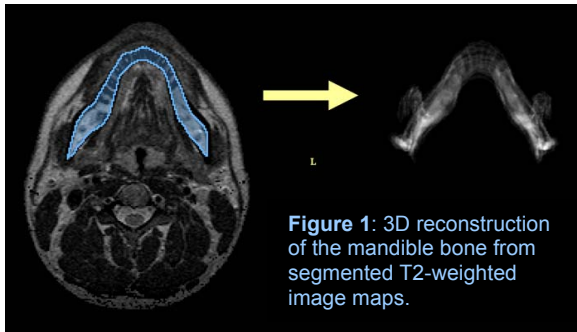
3D reconstruction of the mandible bone from segmented T2-weighted image maps.
